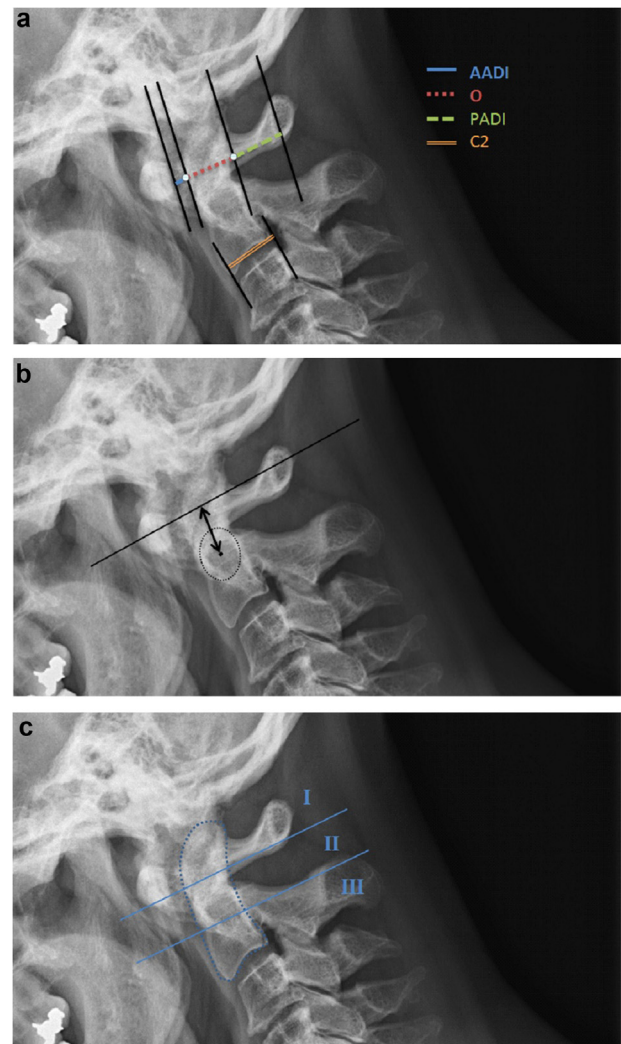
Lateral flexion plain radiograph showing the method used for the following measurements: a: anterior atlanto-dental intervals (AADI), posterior atlanto-dental intervals (PADI), odontoid sagittal diameter (O) and axis body base sagittal diameter (C2); b: Ranawat criterion (double arrow): the distance between the centre of the second cervical pedicle and the transverse axis of the atlas; c: Clark station: the odontoid process is divided into 3 equal parts or stations. The position of the anterior arch of the atlas is assessed relative to these stations.
